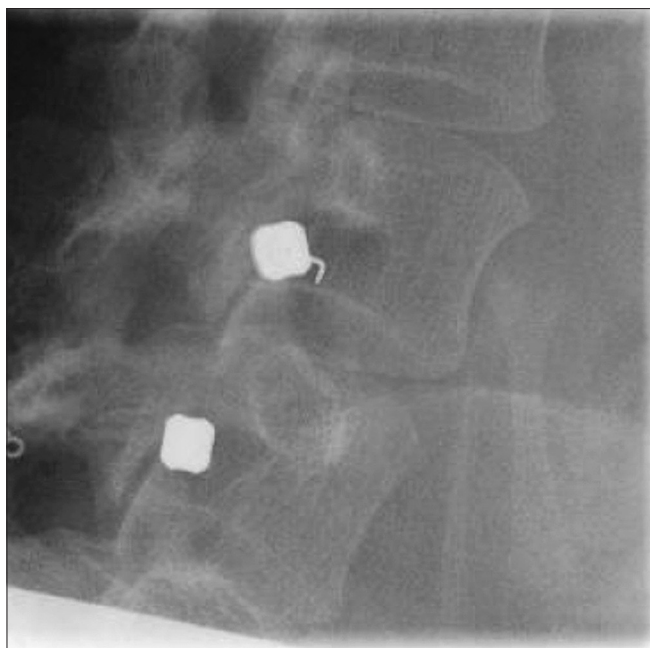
X-ray imaging during nerve root block. L4–L5 root block using 2.5 mL of 1% mepivacaine for each nerve root
